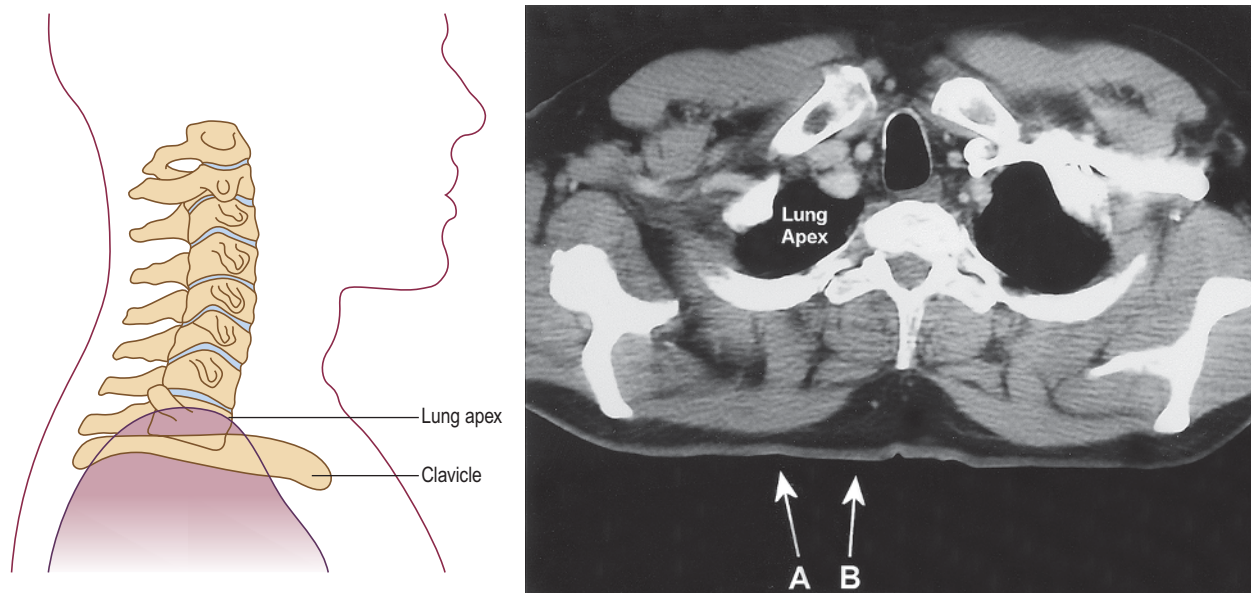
Lower cervical paraspinal muscles and the risk of pneumothorax. Left: In some individuals, the lung apex rises above the clavicle where it may be punctured from a laterally placed electromyographic needle. Right: Axial computed tomographic scan of a normal individual at the C7–T1 vertebral level. Note that the correct location for sampling the paraspinal muscles is (B), just off the midline with the needle directed down and slightly medially. If the needle is placed too laterally (A) and directed deep and lateral, there is a risk of pneumothorax at this level in some individuals.
